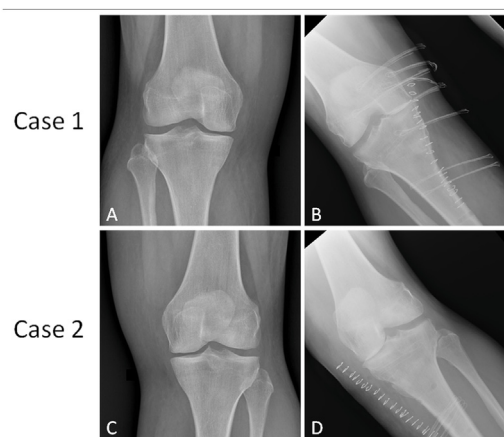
Two representative cases affected by knee disorders with K-L 2 grade osteoarthritis, that underwent high tibial osteotomy and were treated with BMAC injections. A) and C): pre-operation standing anteroposterior knee radiography. B) and D): knee radiography taken 3 and 2 years after BMAC treatment respectively.
